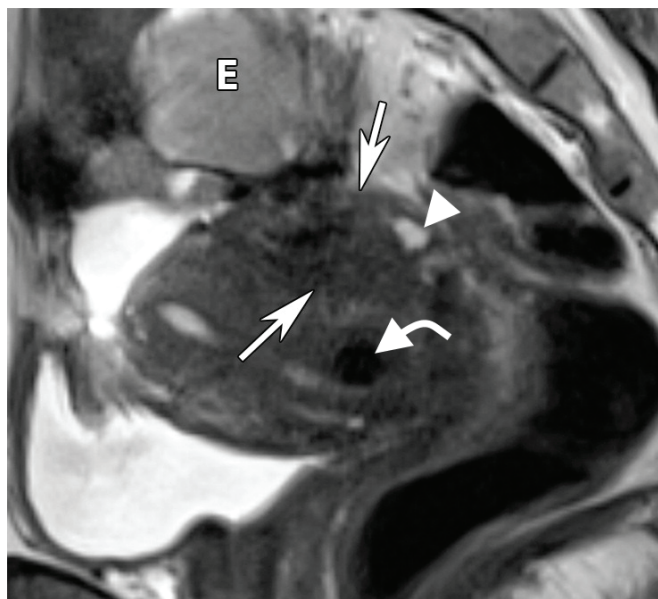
Sagittal T2-w MR image in a case of endometriosis showing an ill-defined mass (arrows) infiltrating the posterior wall of the uterus and cervix and the anterior wall of the rectum. The mass contains hypointense foci (curved arrow) due to haemosiderin content and hyperintense foci (arrowhead) due to blood. A hyperintense mass (E) seen superior to the uterus represents an endometrioma.
